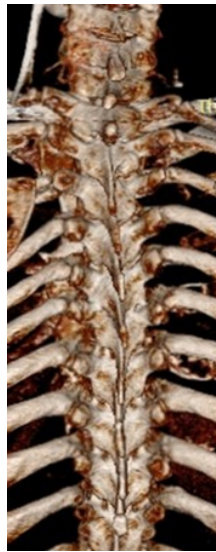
Scoliosis on 3D CT scan of the chest
